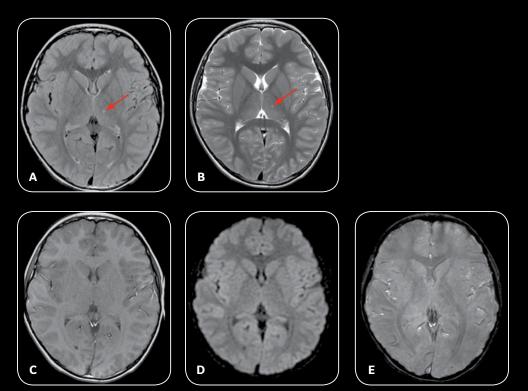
A 7-year-old patient referred for investigation of non-specific abnormalities on physical examination. (A, B) Axial T2 FLAIR and PROPELLER demonstrate a subtle punctate non-specific lesion in the left thalamus. (C-E) No evidence of endured perinatal asphyxia, other basal nuclei have a normal aspect.
